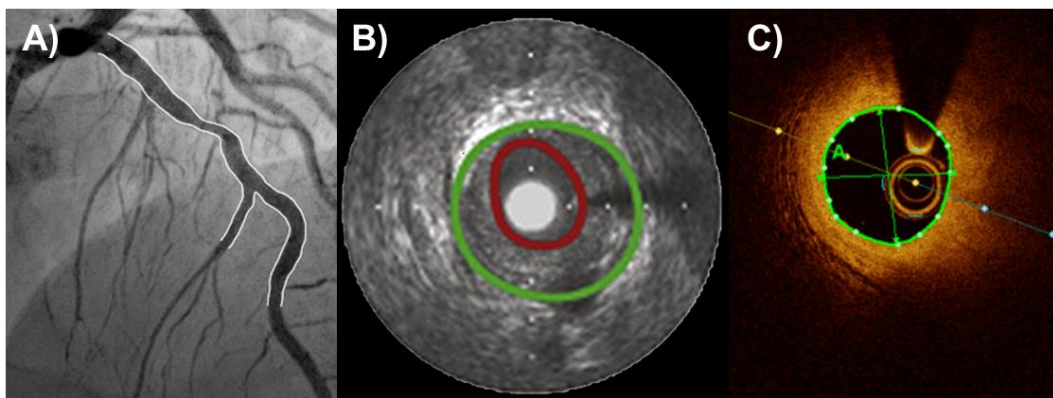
Techniques for invasive anatomical assessment of CAD. A) Invasive coronary angiography (ICA); B) intravascular ultrasound (IVUS); C) optical coherence tomography.
